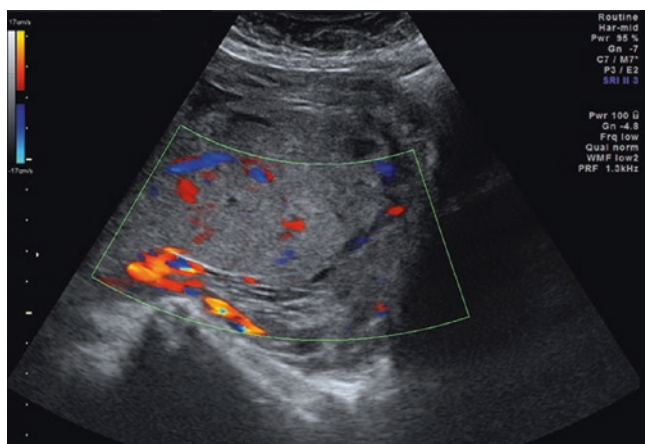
Placenta previa at transabdominal ultrasound: absence of color Doppler signs of accretism
